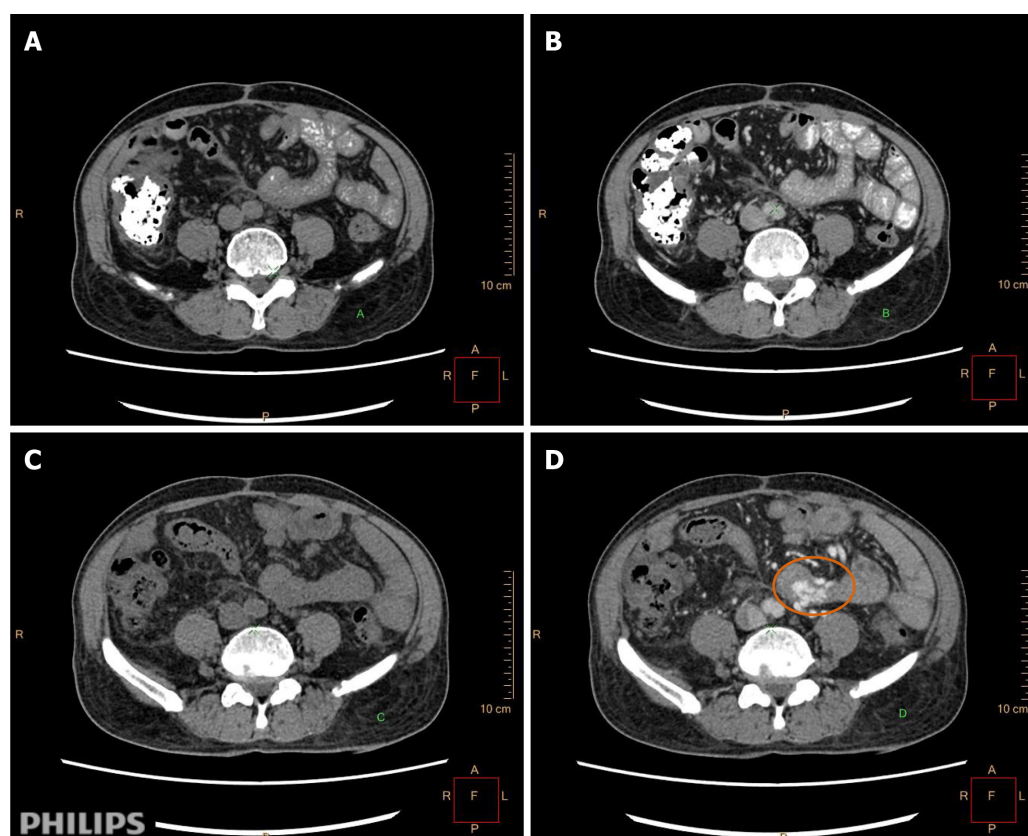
Abdominal computed tomography enhancement scan with intravenous iodixanol-320 administration. A and B: Scans, imaging and physical examination were normal on May 29, 2019; C and D: Enhancement, numerous enlarged branches of the blood vessels of the jejunum and tortuous irregular vessels (orange circle).
